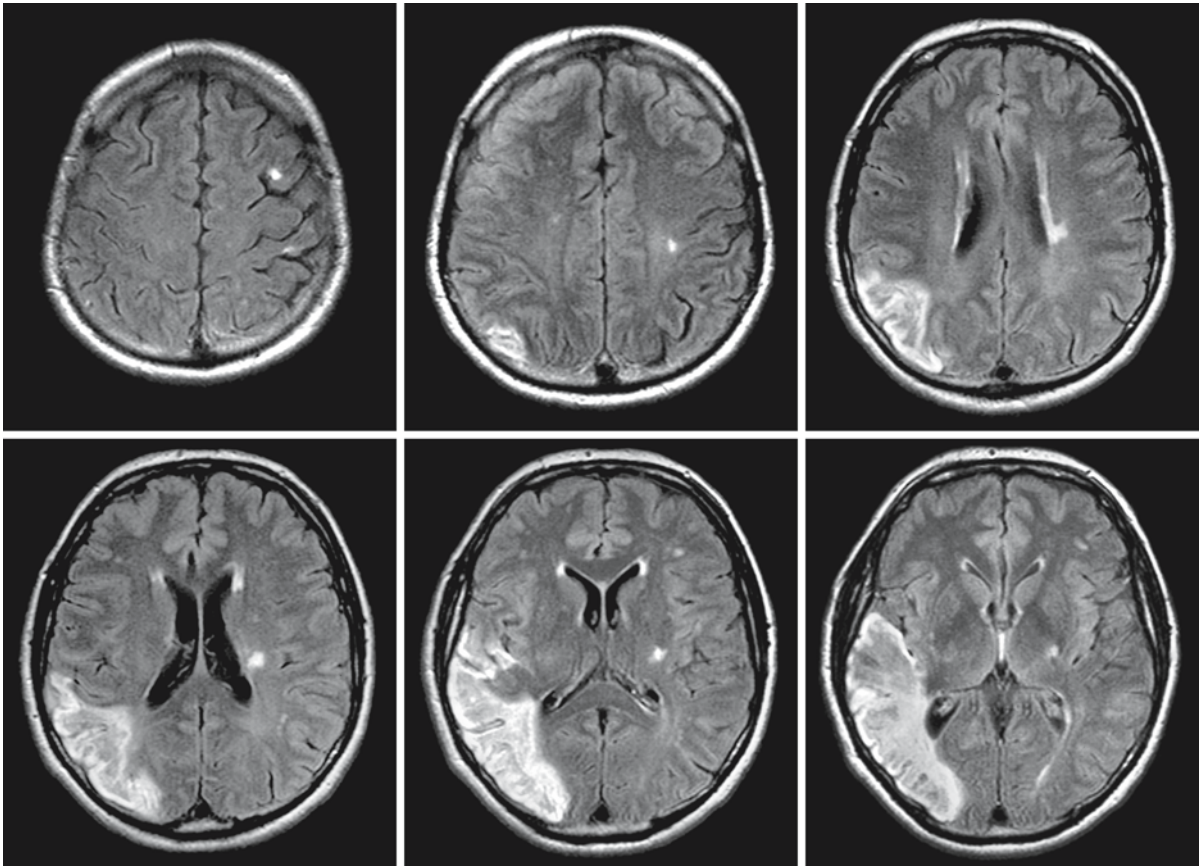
A 57-year-old woman with multiple stroke-like episodes over the years. FLAIR images show a large temporo-parieto-occipital infarct on the right side and several lesions in the left hemisphere, with some focal cortical atrophy. Note that the distribution of the infarction does not reflect a single
